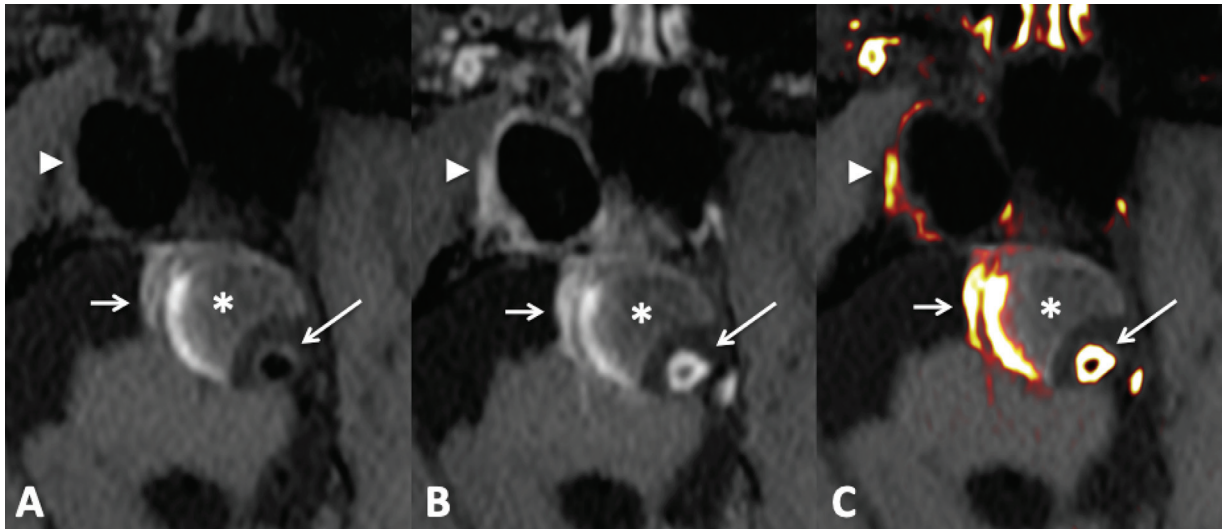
Vessel Wall MRI. Precontrast (A), postcontrast (B), and image fusion (C) depict the dissecting pseudoaneurysm of the basilar artery composed of a large subadventitial hematoma (asterisks) associated with inflammatory changes (short arrows). Note the circumferential wall enhancement of the basilar artery causing stenosis (long arrows) and right internal carotid artery aneurysm (arrowheads).
